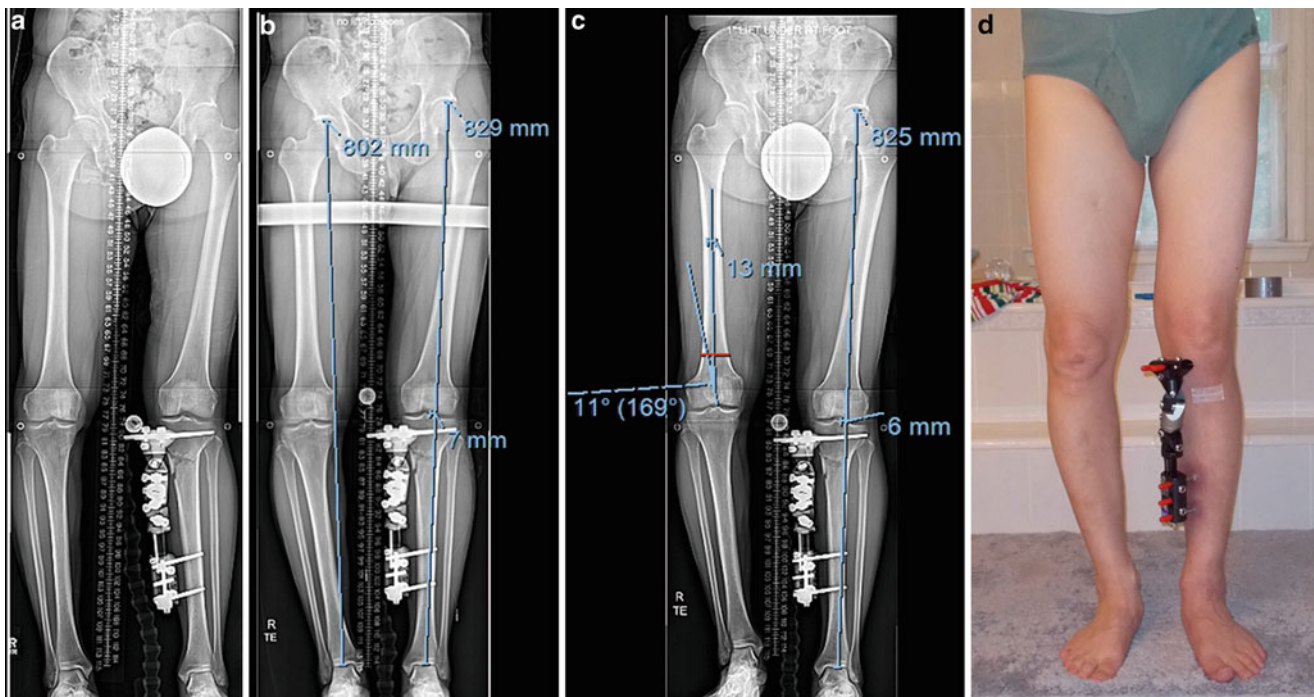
The patient overcorrected the osteotomy creating a butterfly fragment, valgus deformity, and fracturing through the lateral cortex. (a) An acute correction in the office was well tolerated. He was encouraged to walk on the leg for 1 week when new X-rays were obtained to measure the left side alignment. (b) The MAD was seven lateral, and the new (LLD) was measured at 27 mm. Retrograde
